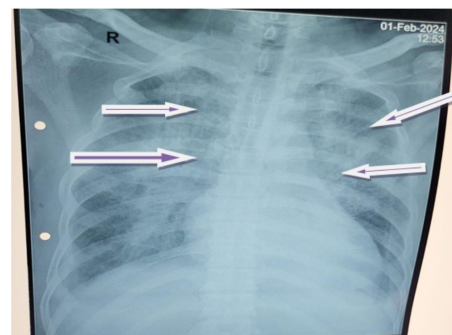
Chest radiograph at the outset of symptoms showed bilateral infiltration (arrow).
